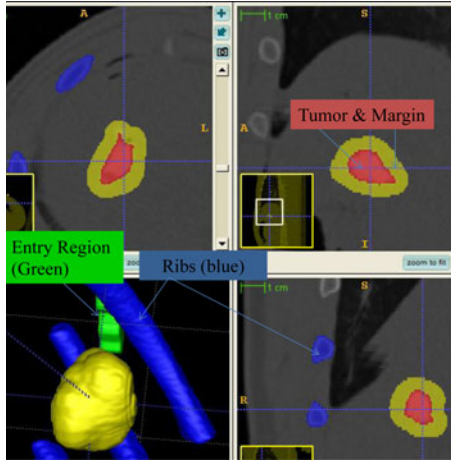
Preoperative CT scan overlaid by tumor region, ribs, preferred ablation probe entry region and safety margin. The region with red denotes the tumor within liver. Green represents the entry region and blue for no-fly-zone. (Refer to the web version of this paper for the color figure.)
